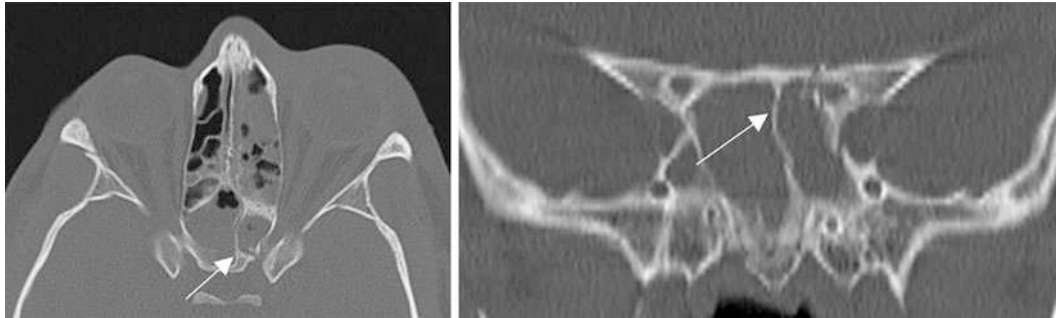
CT scan axial and coronal bone windows: Left optic canal fracture presenting as traumatic optic neuropathy
